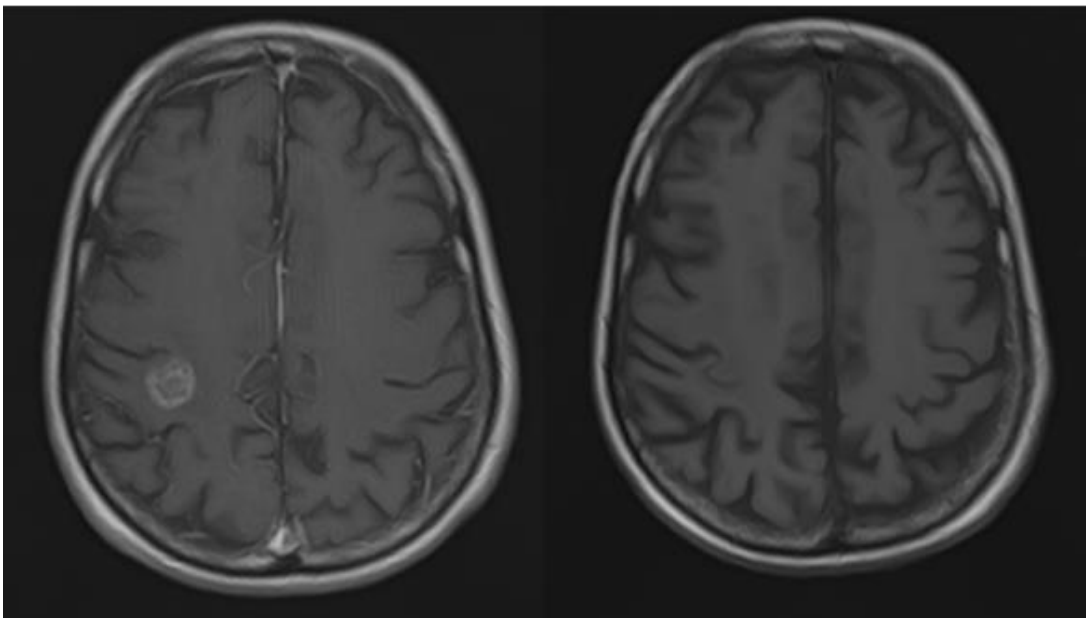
MRI Brain: Left: small rounded hyperdensity measuring 1cmx1.5cm x 1cm at the right parietal lobe suggestive of brain abscess. Right: Resolution of the brain abscess after Day 40 of antibiotics.
